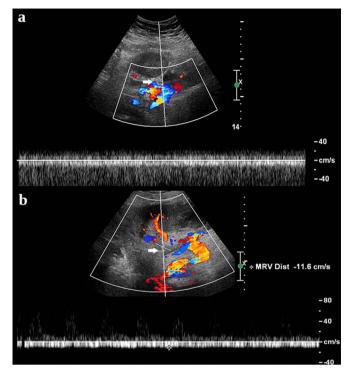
Transplant renal duplex Doppler sonogram. a. Post-transplant day 12 demonstrating partial thrombosis of iliac vein (white arrow) adjacent to renal vein anastomosis and associated lack of pulsatility in waveform. b. Post-transplant day 18 demonstrating propagation of iliac vein thrombus (white arrow) with lack of color flow and venous waveforms throughout transplant kidney.
